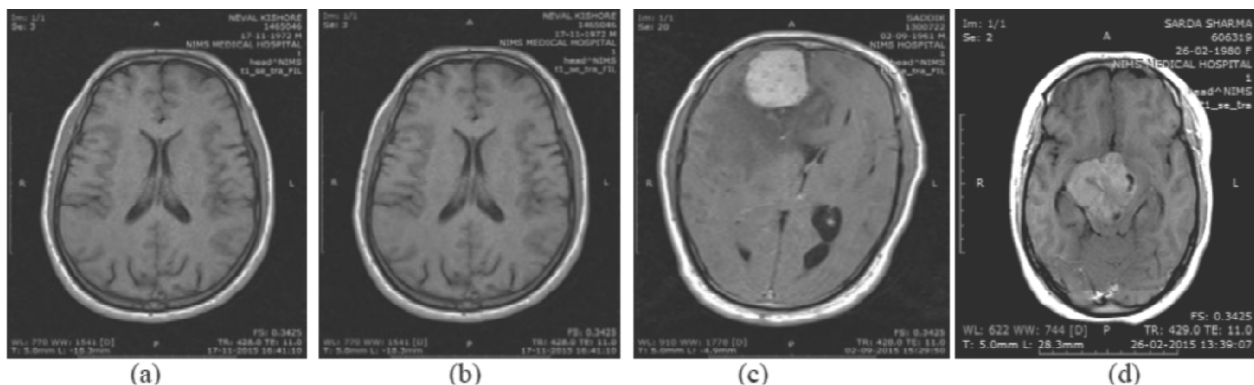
Brain MR images from testing set (a) and (b) are the Normal MR images and (c) & (d) are the Abnormal MR images.
